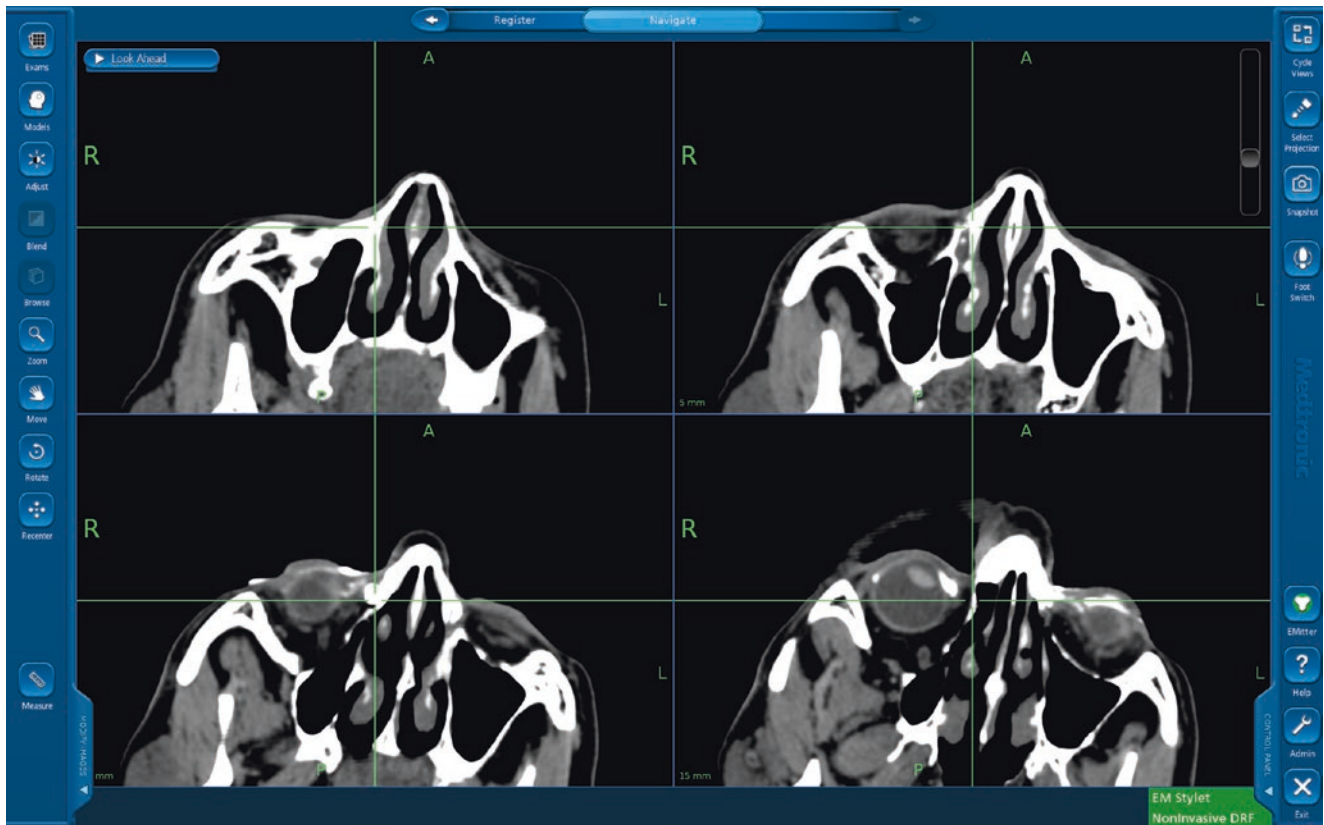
Navigation with look ahead protocol. Note the top left CT scan; axial cut is at the location of the endoscope. The top right is the structures at 5 mm ahead in the straight trajectory of the endoscope. Note the just faint appearance of the lacrimal dye here. The left lower panel is 10 mm ahead from the endoscope. Note the green cross hairs
